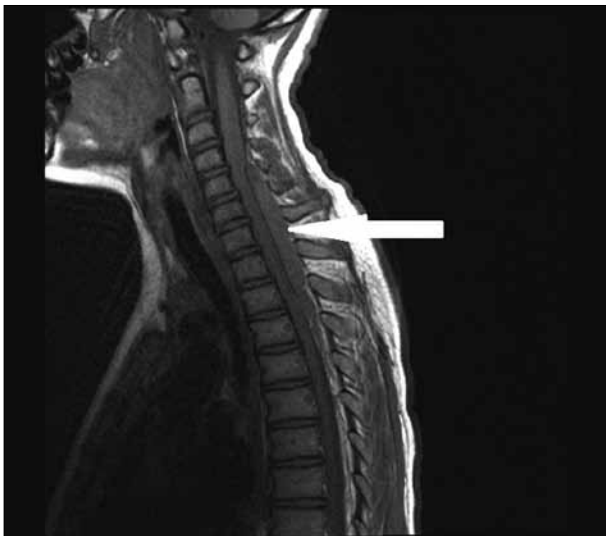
Preoperative MRI of cervical spine, epidural hematoma C5-Th3
